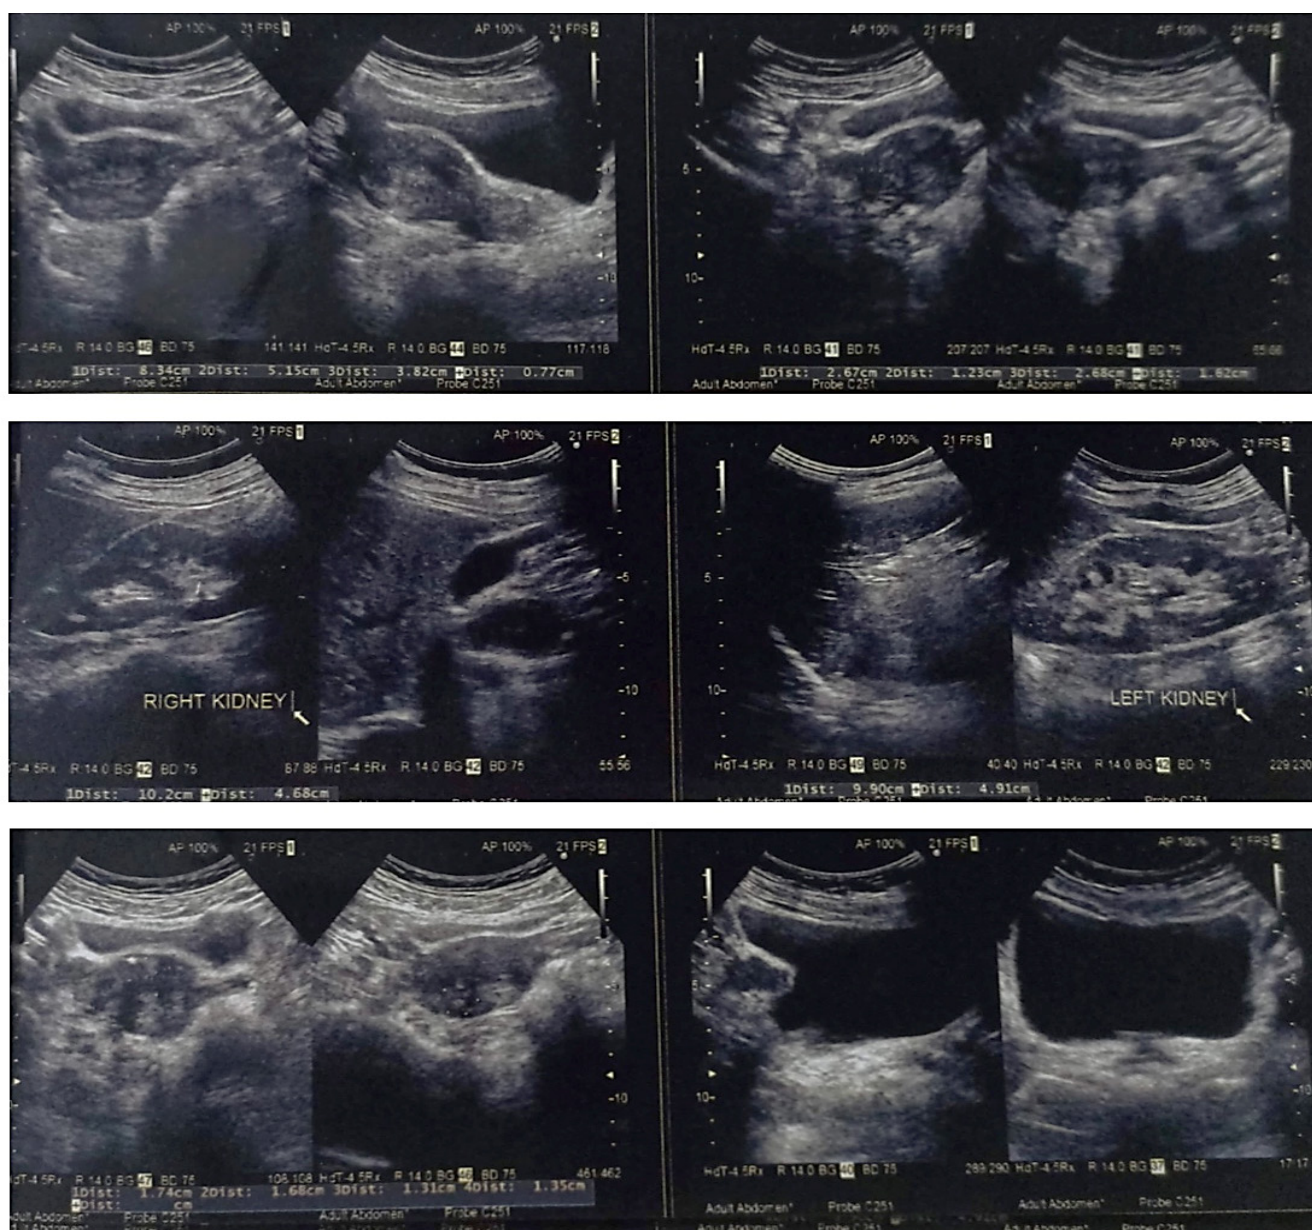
Real-time ultrasound sonography of abdomen and pelvis pre treatment.
